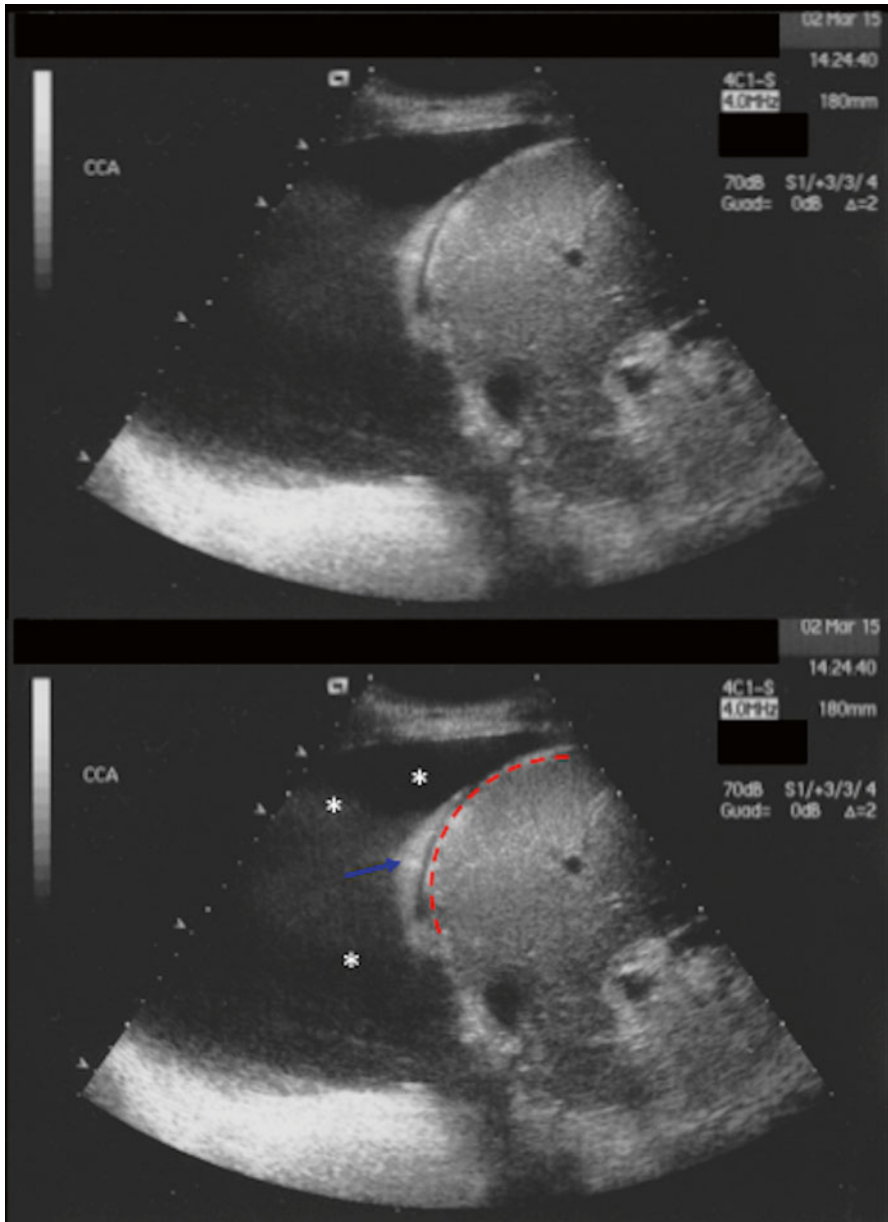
Effusion. The *red line* identifies the diaphragm that separates hepatic parenchyma and thoracic cavity. *White asterisks* are placed in the cavity occupied by the pleural effusion (hypo-/anechogenic). *Blue arrow* indicates the portion of lung parenchyma visible in this sonographic exam (Reprinted with permission from Medical Evidence Percorso Formativo 2015, year. 8, n. 104, www.ati14.it)
